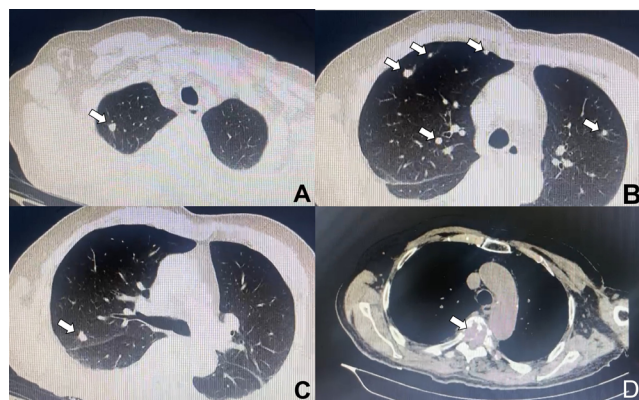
A, B and C. Chest tomography - arrows indicate multiple rounded solid nodules, in both lungs; D. Axial slice from a computed tomography showing fracture of the fourth thoracic vertebra (T4).
